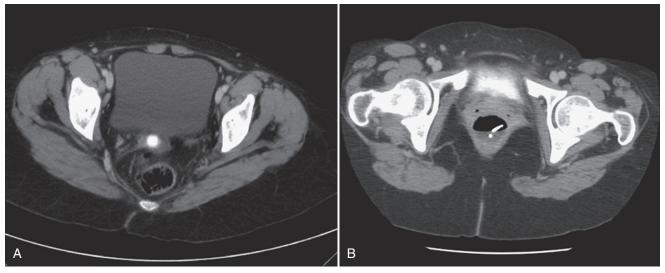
A, Computed tomography (CT) of the pelvis shows an abscess that measures 80×60 mm. B, After EUS-guided drainage, a follow-up CT scan at 36 hours demonstrates nearly complete resolution of the abscess.
